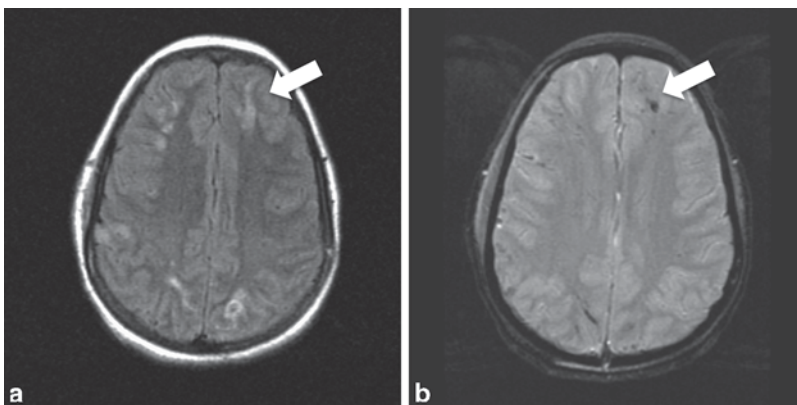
a Axial MRI FLAIR sequence showing bright signal (*arrow*) of diffuse axonal injury and b Axial MRI gradient sequence showing dark signal (*arrow*) indicating hemorrhage in same area. (Courtesy of Dr. Blaine Hart)
